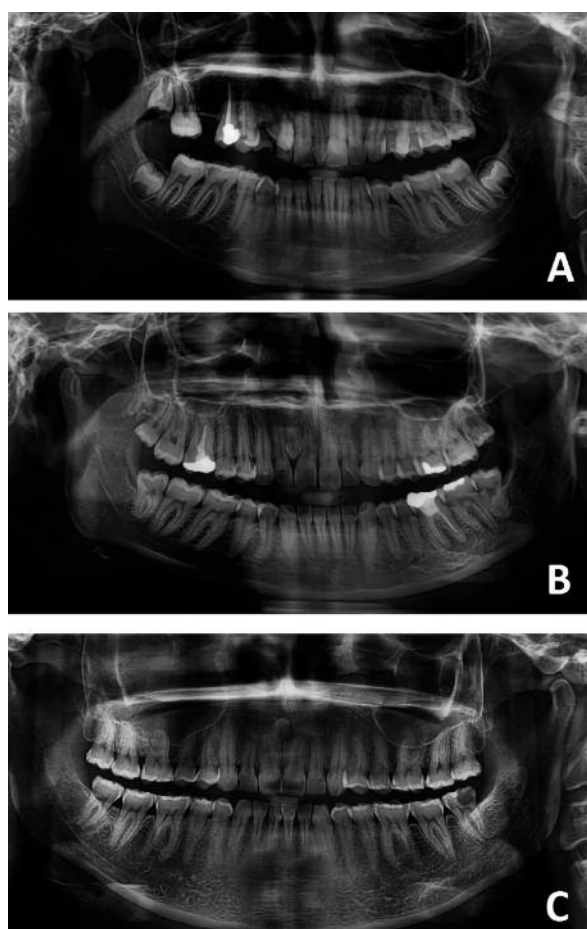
Panoramic radiographs showing mesiodens in different directions. A-B, Vertical. C, Horizontal.
